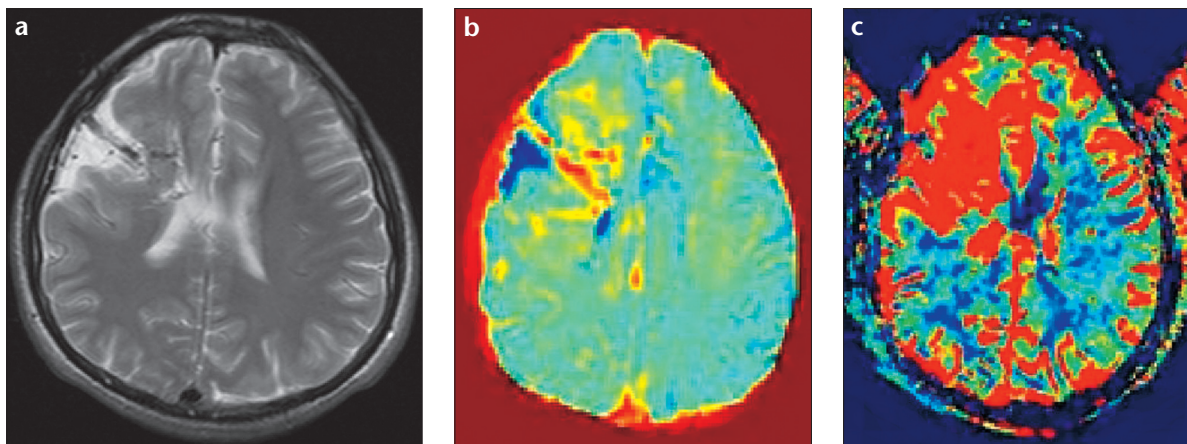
a-c. Patient 1. Relative cerebral blood volume map of a patient with a giant developmental venous anomaly (DVA) associated with cortical dysplasia. Transverse T2-weighted MR image (a) shows DVA and cortical dysplasia. rCBV map from homemade software (b) and rCBV map from commercial software (c) are shown.
